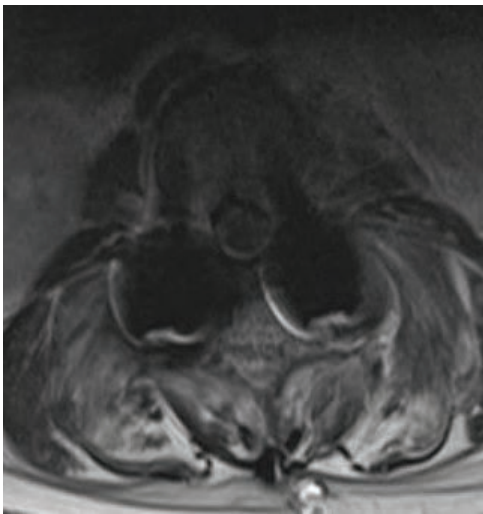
Most severe level of stenosis on axial MRI cuts postoperatively at L1-2 level.
